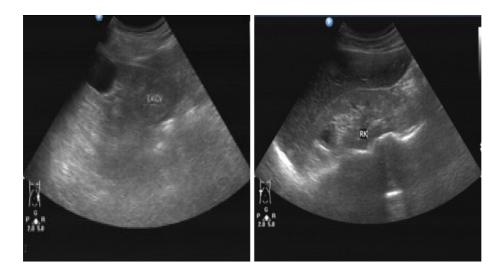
Renal ultrasound findings of the patient, revealing relatively atrophic kidneys with multiple secondary cysts.
